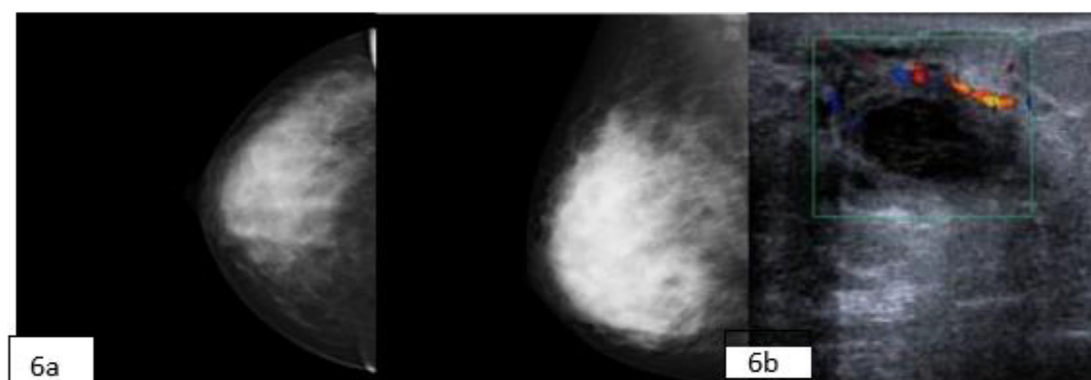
Breast cyst: A female patient 41 years old. A history of right breast lump. (a) Craniocaudal and mediolateral views of the right breast display heterogeneously dense parenchyma which may obscure small lesions (ACR C), (b): ultrasound of the right breast revealed retroareolar complex cystic lesion with posterior enhancement, thick wall and peripheral vascularity.
